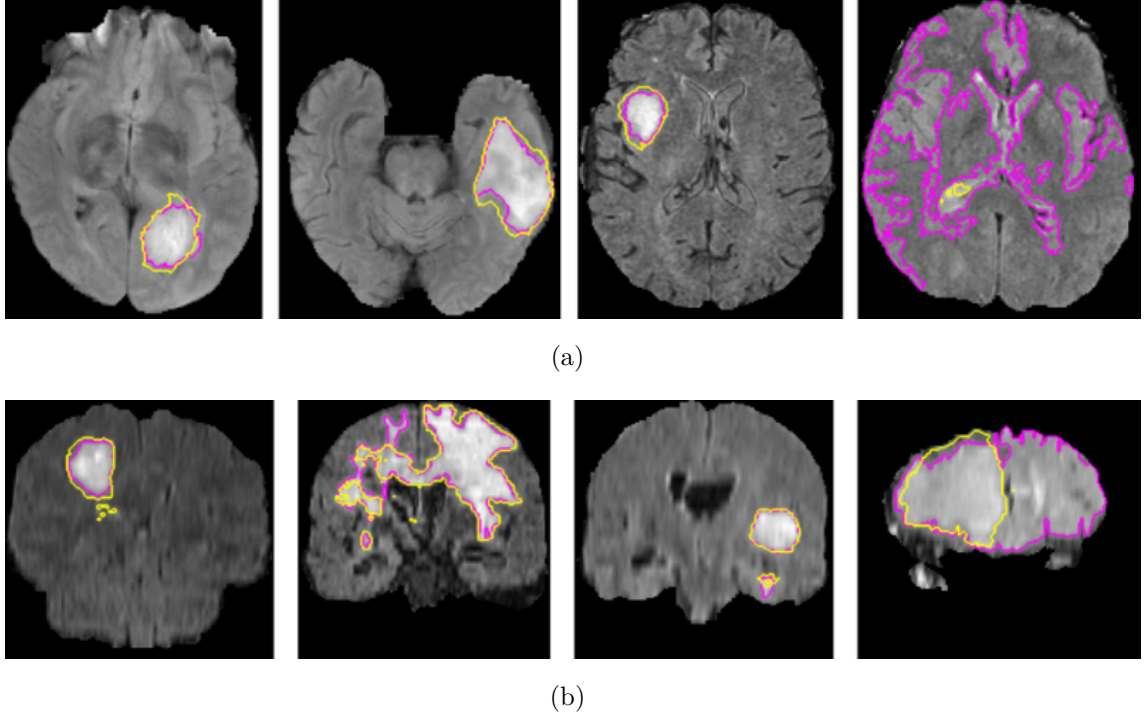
Examples of the brain tumor extraction using the unsupervised algorithm in 2D (a) axial and (b) coronal FLAIR slices. A comparison of manual annotation (yellow) and automatic extraction (magenta) is depicted.
